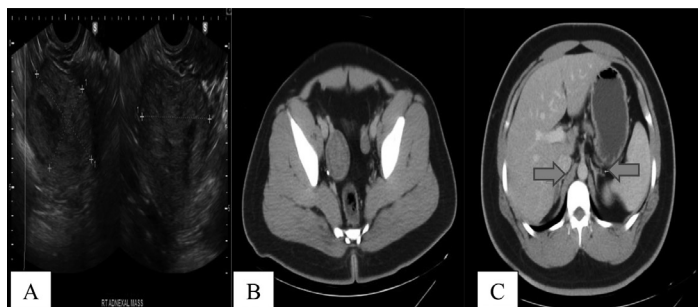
(A) Right adnexal mass on Transrectal ultrasound. (B) Abdominal mass likely ovarian in origin on CT Scan. (C) Normal bilateral adrenal glands on Abdominal CT Scan
